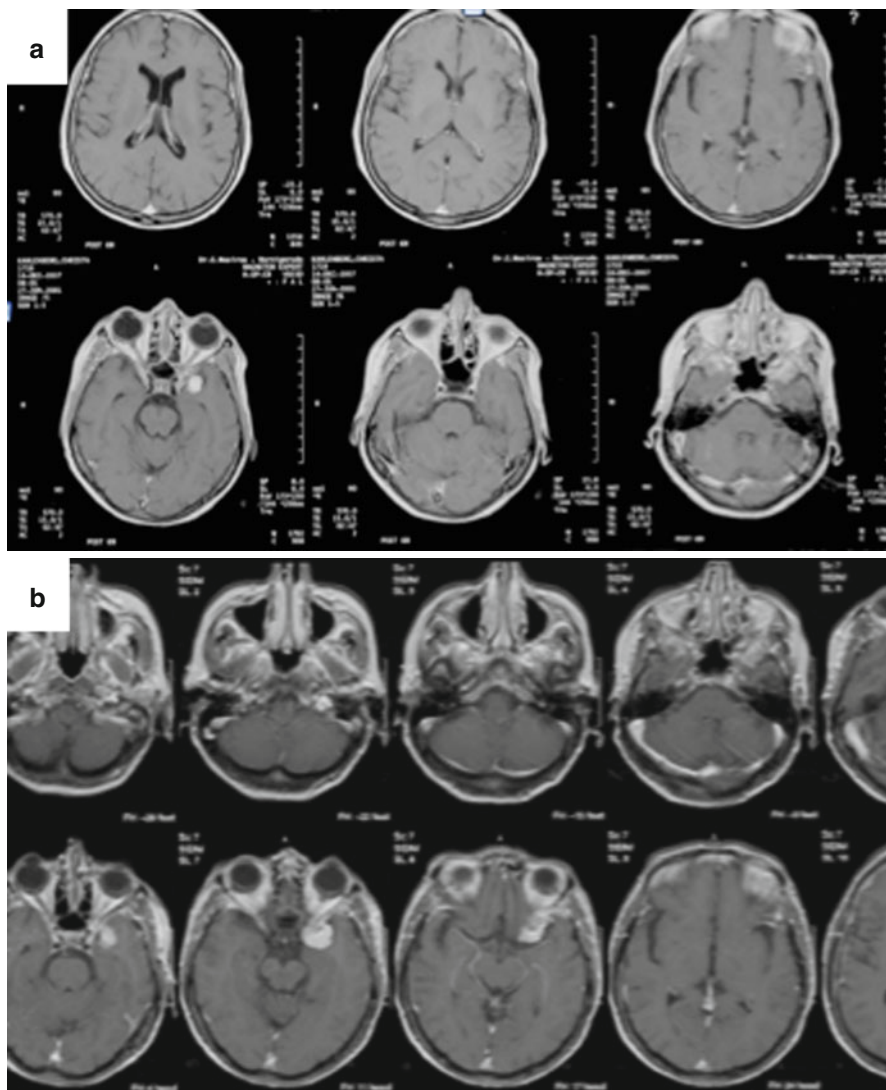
Spontaneous course of a meningioma in 5-year interval – first, headaches and then visual problems due to close connection to optic nerve. (a) 2001: Only one axial MRI slice in which the meningioma is seen; (b) 2006: 3 axial slices depicting the grown meningioma
